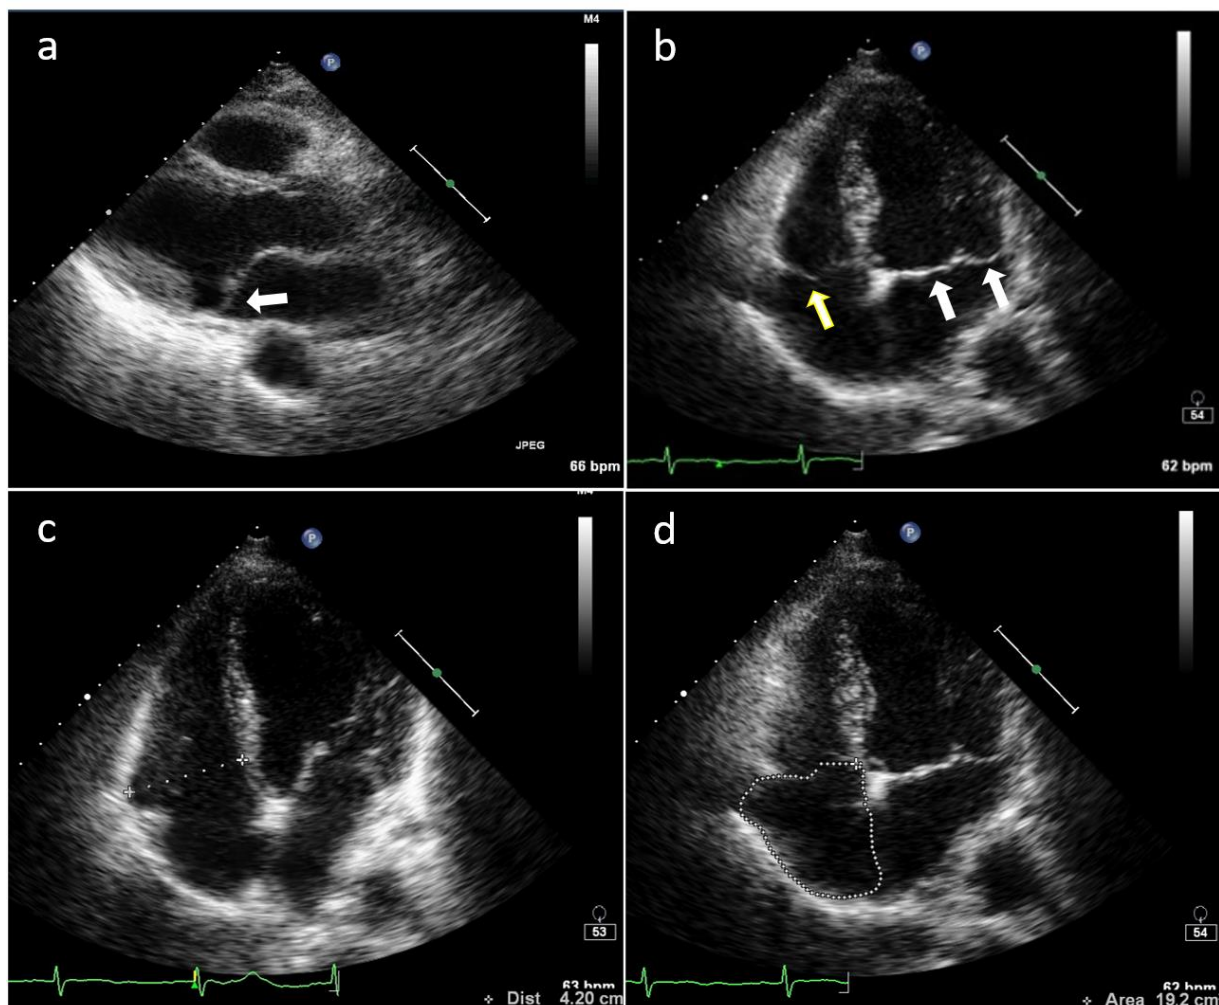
Transthoracic echocardiography, performed in the acute phase, showed the presence of mitral valve prolapse, most evident at the scallops P2 (a, white arrow), A3, P1 (b, white arrows), and tricuspid valve prolapse, most evident at the scallop of the anterior leaflet (b, yellow arrow); no mitral annular disjunction nor tricuspid annular disjunction was detected (a, b). Furthermore, the exam showed increased right ventricle cavity size defined by a basal end diastolic diameter of 42 mm (c) and right atrial enlargement defined by an end-systolic area of 19 cm² (d).
